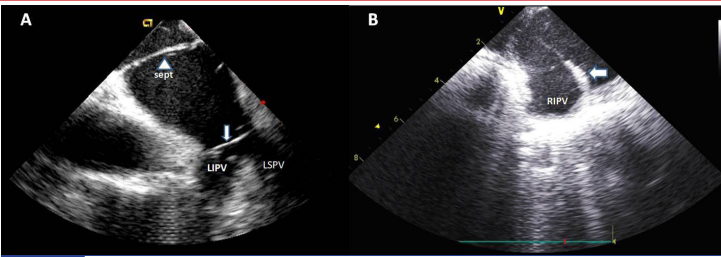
Antral isolation of the left and right pulmonary veins guided by intracardiac echocardiography. Panel A: Lasso catheter was placed in the left common ostium between the left inferior and superior pulmonary vein (white arrow). Panel B: Ablation catheter (white arrow) is touching the right venous carina next to the right inferior pulmonary vein. LSPV: left superior pulmonary vein, LIPV: left inferior pulmonary vein, RIPV: right inferior pulmonary vein, Sept: interatrial septum. Images are originating from the database of Szeged University.
